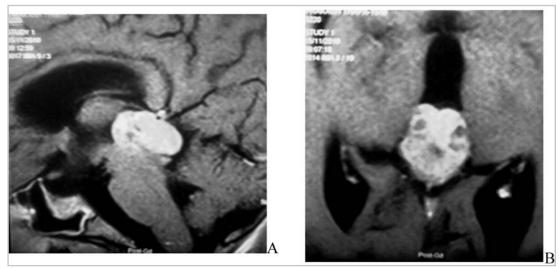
MRI scans. Mass at the projection site of pineal gland extending to posterior 3rd ventricle and quadrigeminal plate cistern. Close-up (Post Gadolinium) views A) Sagittal view, B) Axial view.
